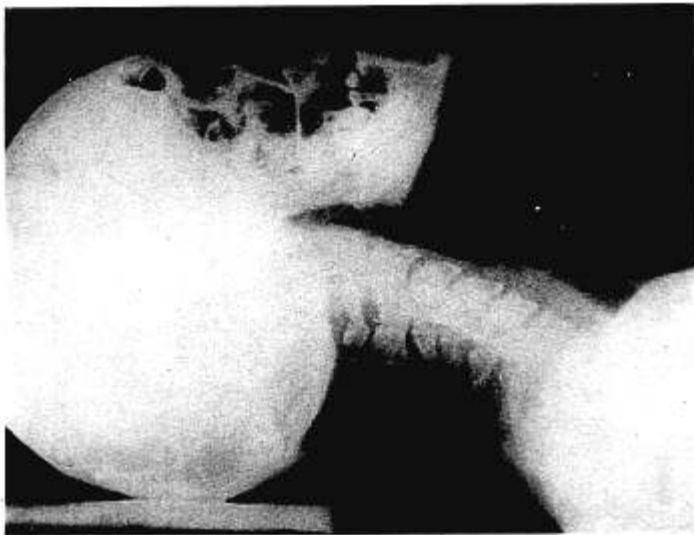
Roentgenogram of air passages of head and neck. Head is raised in "amended" position. The arrow shows approximate position of vocal cords.
